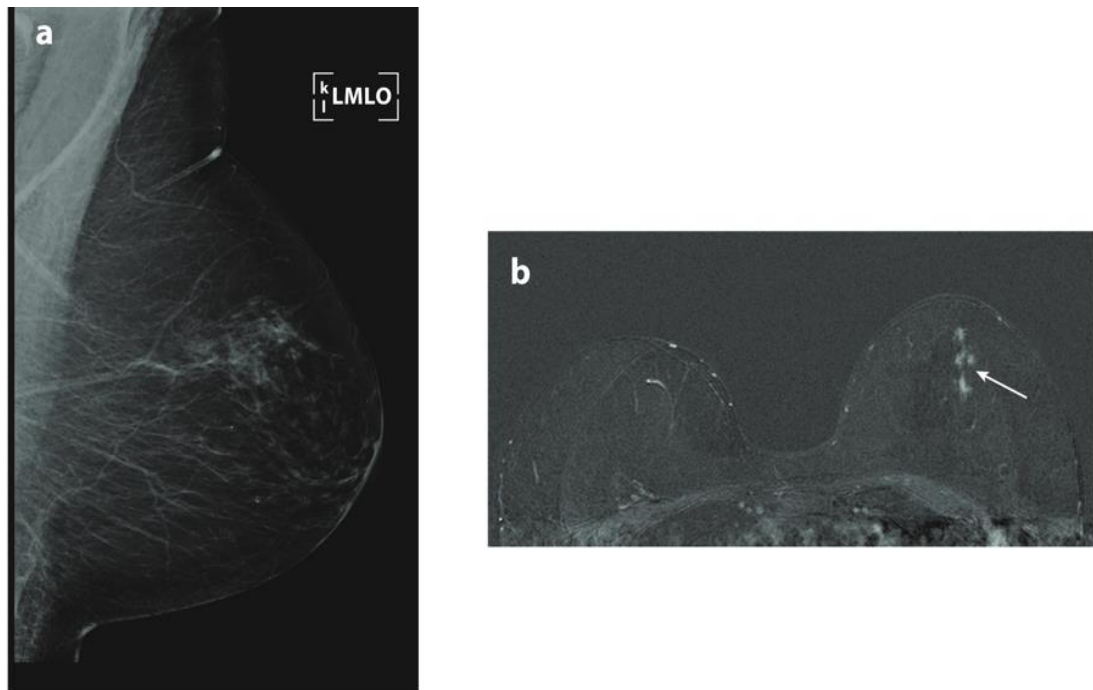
Example of a mammography-occult biologically aggressive cancer (a) Mammography with no evidence of breast cancer or dense breasts. (b) Ductal enhancement present in an abbreviated MRI (biopsy proven- high grade DCIS) (Kuhl et al., 2019).
